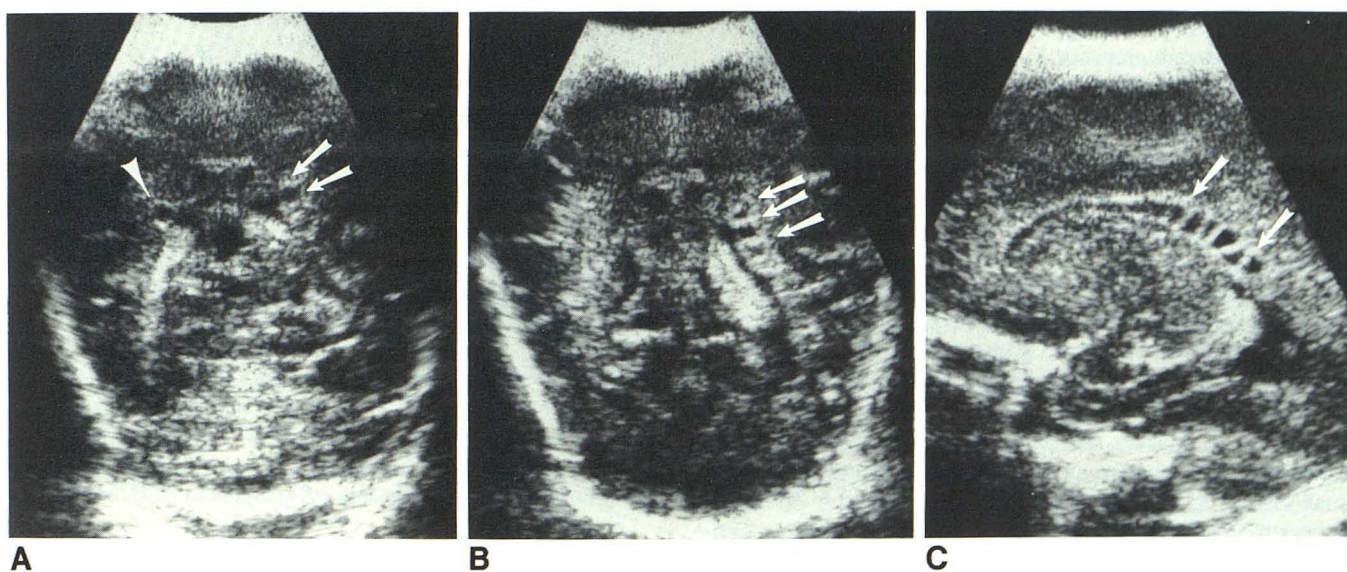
Case 6. Coronal semiaxial (A and B) and left parasagittal (C) sonograms show solitary right frontal cavitation (arrowhead) and linear cluster of polygonal cavitations along frontal horn and body of left lateral ventricle (arrows).
